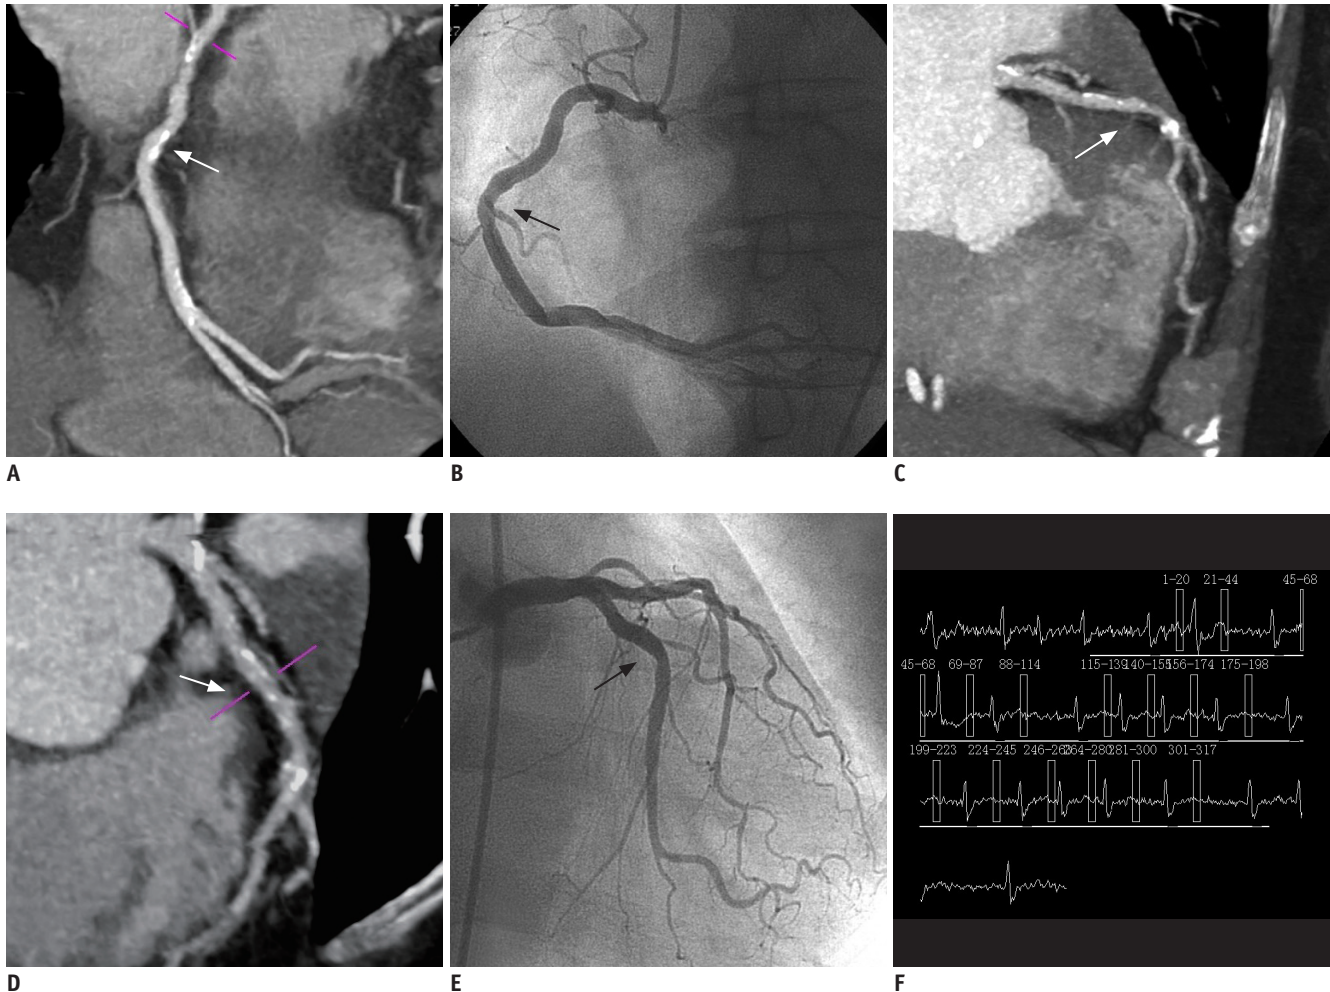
CT angiography of 70-year-old woman with atrial fibrillation (mean heart rate: 87 bpm, range: 60-125 bpm). A. Curved multiplanar image showing slight stenosis in right coronary artery segment 1 (arrow). B. Invasive angiography of right coronary artery confirms presence (arrow) of mild lesion. C, D. Maximum intensity projection image (C) and curved multiplanar image (D) showing slight stenosis and accompanying atherosclerotic lesions in left anterior descending artery segment 7 (arrows). E. Invasive angiography confirms presence of lesion (arrow). F. Echocardiography is shown (reconstruction at 300 ms of cardiac cycle).
